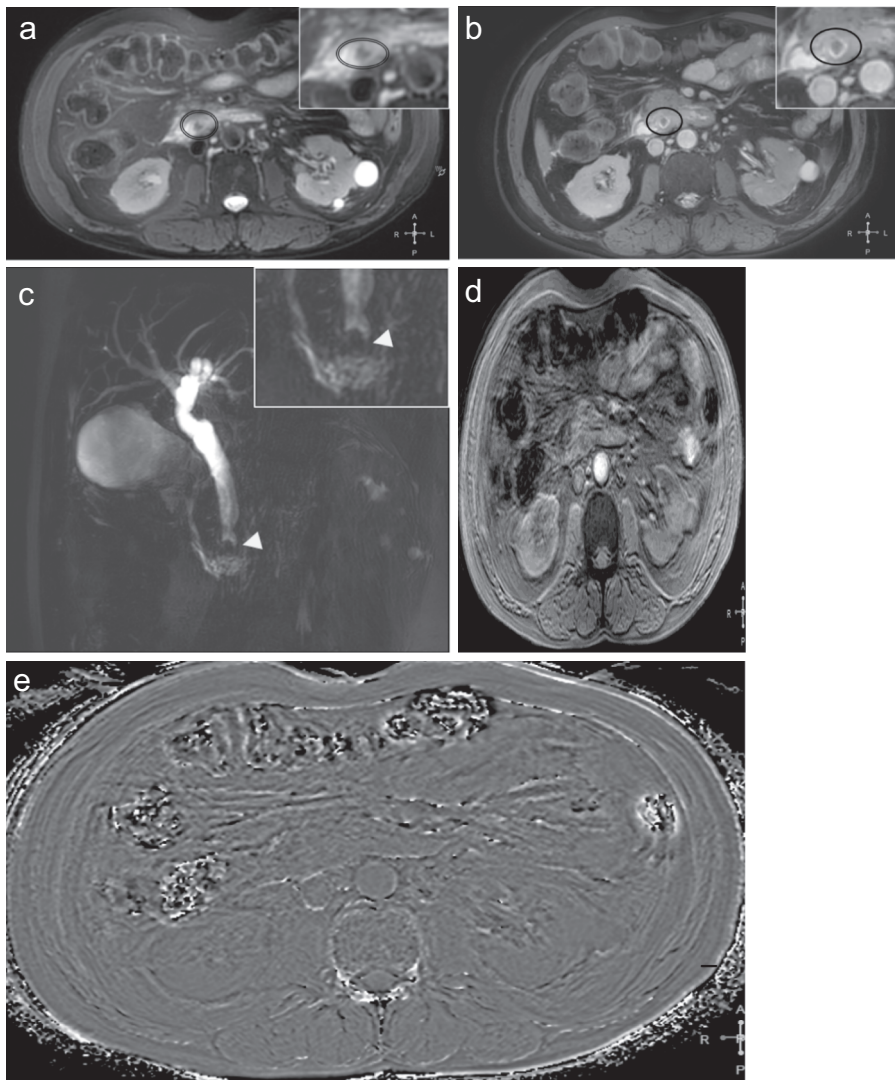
a-e. Stone not visualized in SWI—comparative collage of images from the same anatomical level, from one of the patients where the CBD stone was not visualized in SWI data. T2-weighted (a), BTFE (b), and MRCP (c) images indicated the presence of a calculus in the same location. SWI data, magnitude (d) and phase (e) images, do not show signal changes or susceptibility signature in the corresponding region. This may be because of slight motion blurring that is seen in the SWI data.
